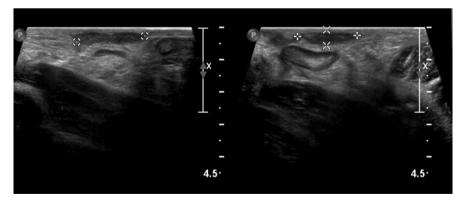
Follow up ultrasound showed significant reduction in the size of abscess to 1 ml with multiple reactional Lymph nodes.
